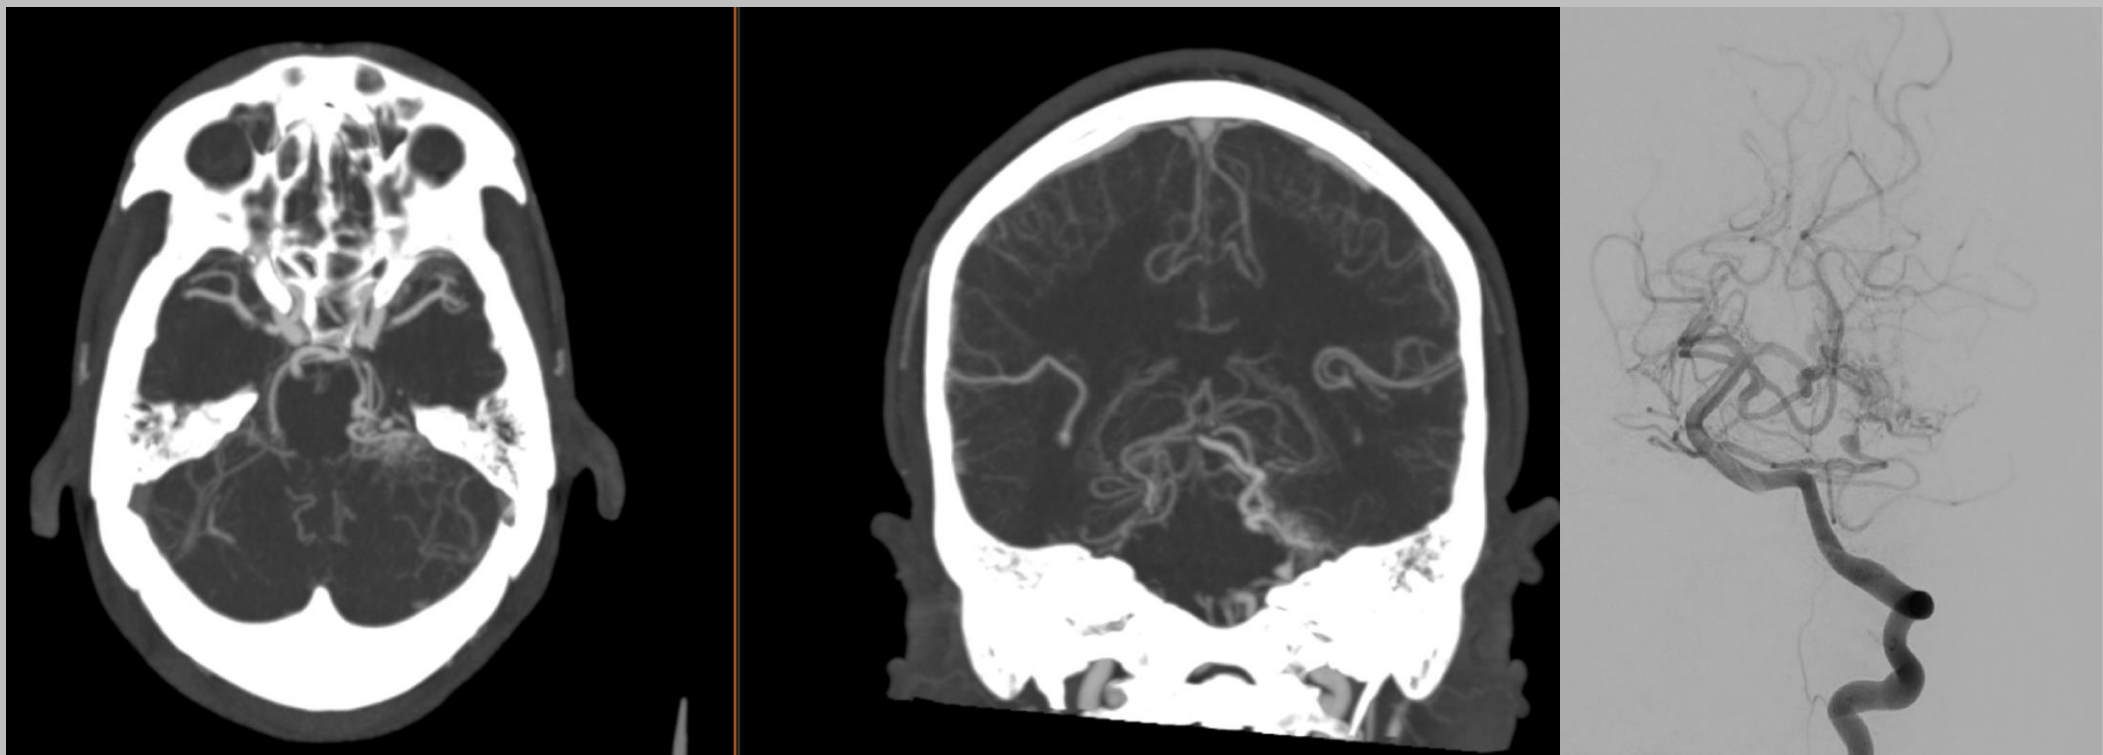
Admission CTA and cerebral angiogram of L VA (AP)
